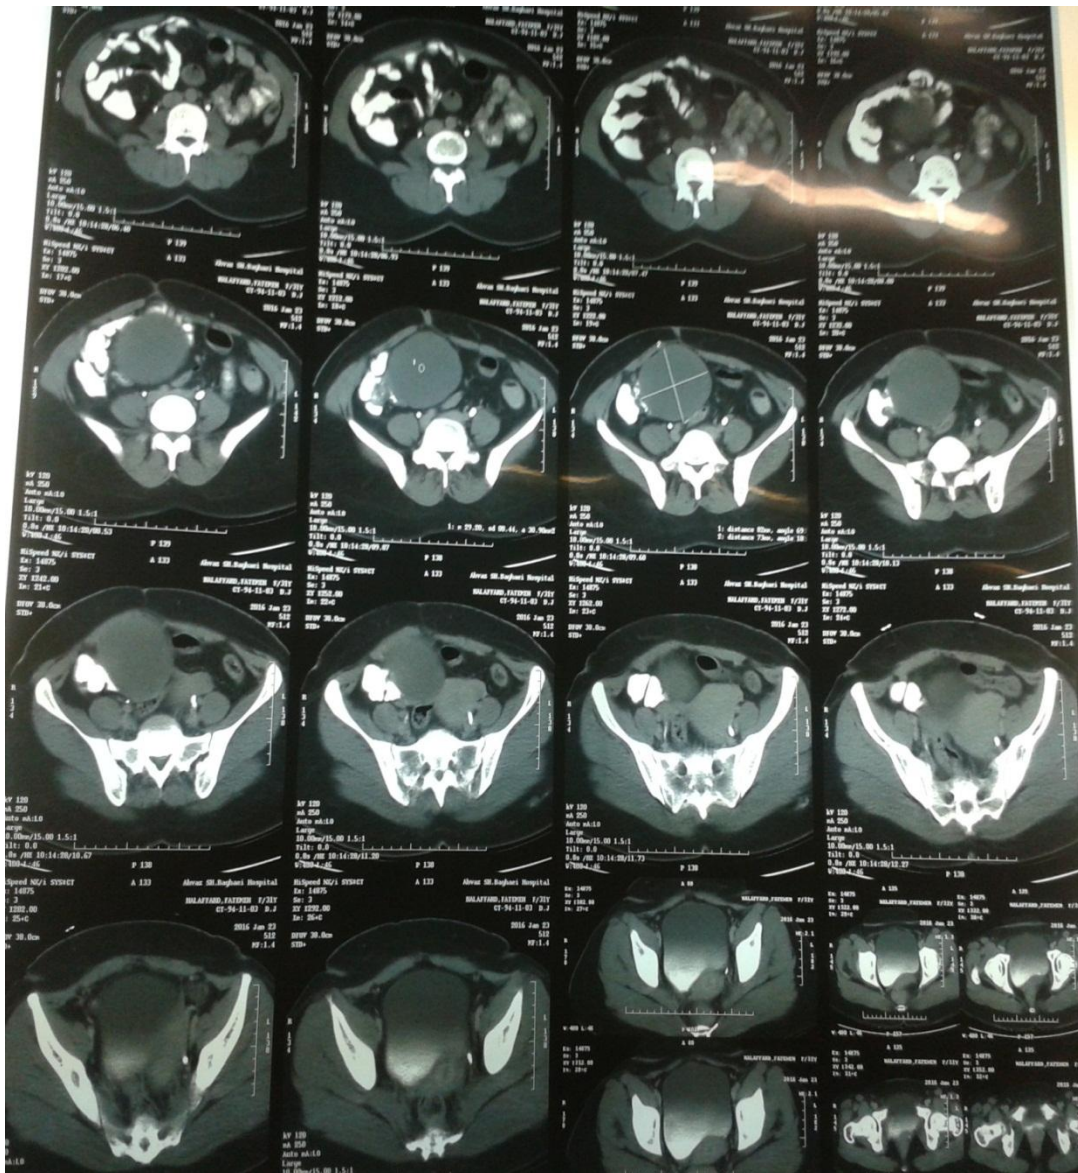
Abdominal CT scan, showing right side cystic mass
